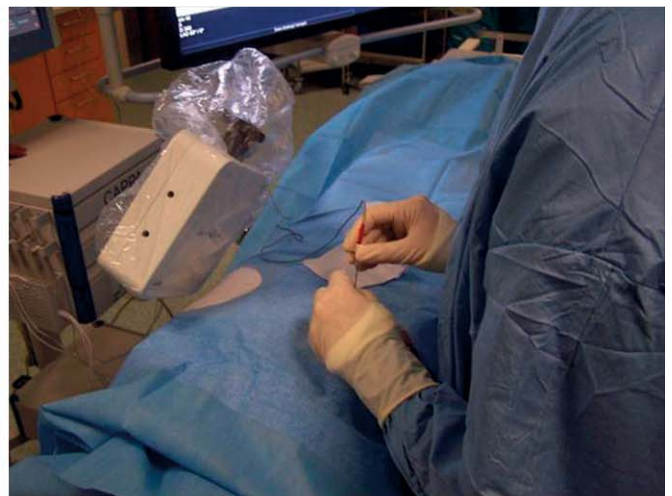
Situation während einer FD-CT-/EMN-gesteuerten Biopsie nach FD-CT-Akquisition. Linkes Bild: Unter sterilen Bedingungen wird die koaxiale Führungsnadel innerhalb des elektromagnetischen Wechselfeldes gesteuert, und ein fusioniertes FD-CT-/EMN-Bild wird auf einem separaten Monitor wiedergegeben, sodass eine präzise Nadelinsertion in die Zielläsion möglich ist. Rechtes Bild: Die Manipulation der Führungsnadel in unmittelbarer Nähe zum fest installierten Feldgenerator erzeugt das elektromagnetische Wechselfeld.
